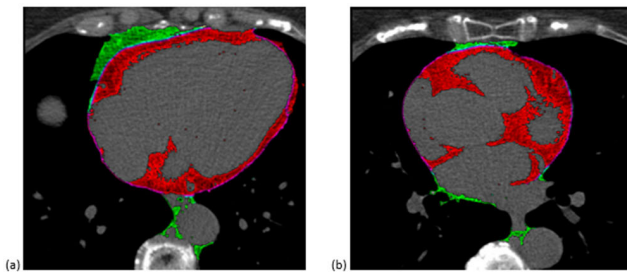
The various sizes, shapes and positions of the epicardial fat of the cardiac CT scans shown in (a) and (b) with red color.
